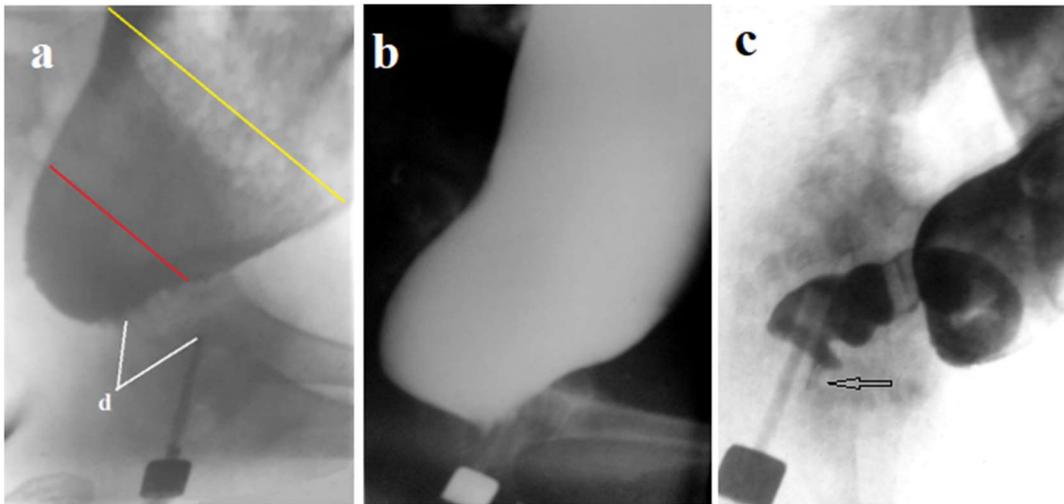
(a-b) Rectosigmoid ratio in HD and in functional constipation (FC). (a) A 10-year-old girl with a short ($d = 2.5$ cm) aganglionic segment, which is in a contracted state. The width of the rectum (red line) is 6.4 cm. A maximum age norm is 4.1 cm. The width of the sigmoid colon is 11 cm. A maximum norm is 2.6 cm). (b) An 8-year-old male with FC. He has a rectosigmoid ratio <1. However, the rectal width is 5.1 cm. It greater than the maximum normal limit (4.1 cm), and the anal canal length of 1.4 cm is significantly less than the minimum normal limit (2.6 cm). (c) An 11-months-old male with HD with a typical x-ray picture of HD. Rectosigmoid ratio <1. The arrow shows the contrast agent that has penetrated the top of the anal canal in front of the enema tip, which can be mistaken for RAIR.
